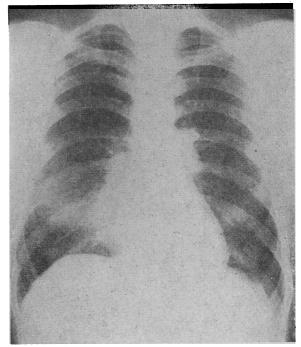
Case 1. Radiograph taken on 5 July 1962.
